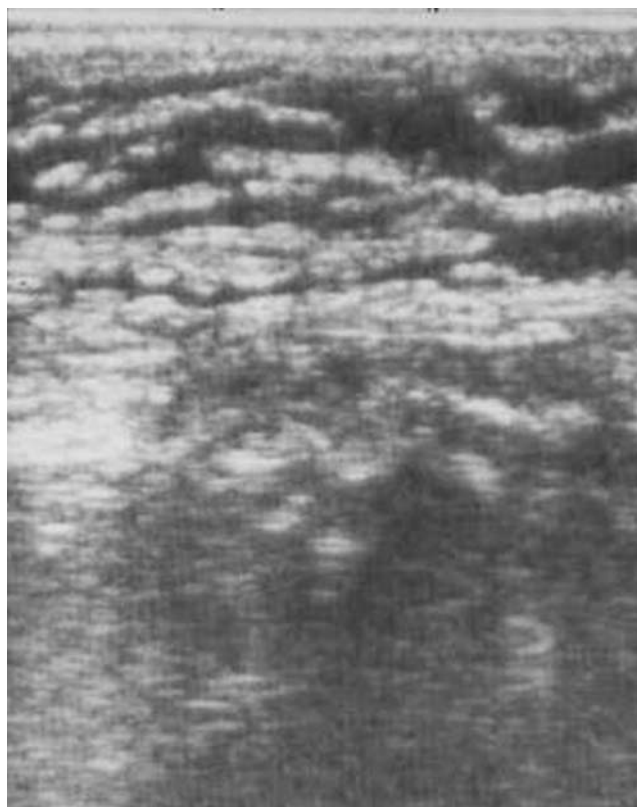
Ultrasound image of cellulitis showing subcutaneous fluid surrounding hyperechoic fat lobules.
